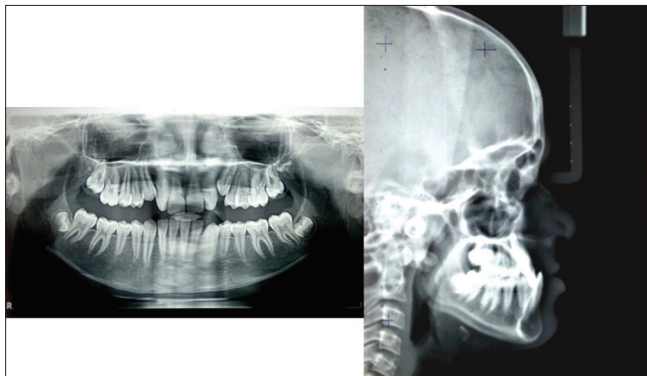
Pretreatment orthopantomogram and lateral cephalogram
